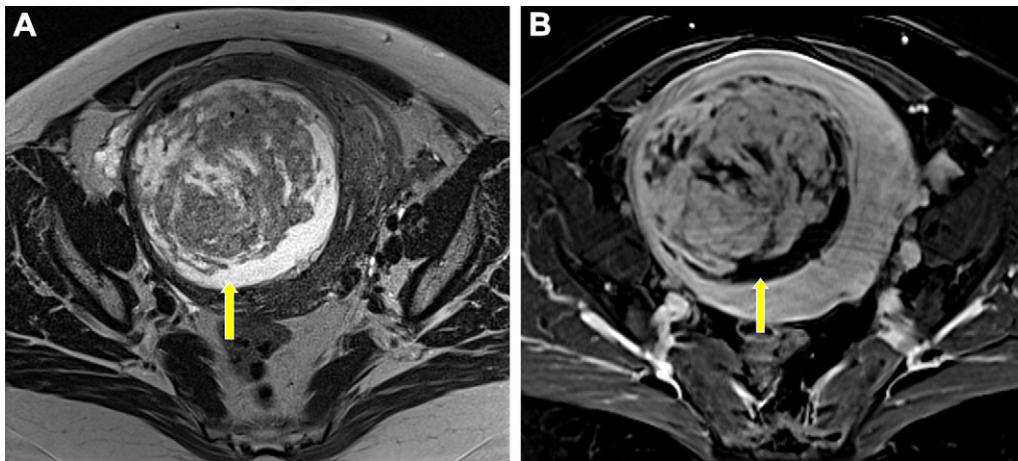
Hydropic leiomyoma in a 51-year-old woman with bulk symptoms, including abdominal bloating, who underwent laparoscopic myomectomy. (A) Axial T2W MR image shows a large FIGO stage 5 leiomyoma (arrow) with heterogeneous signal intensity in the right uterine body. There are confluent areas of T2 hyperintensity, particularly along the periphery of the tumor. (B) Corresponding axial postcontrast T1W fat-saturated subtraction MR image shows a well-demarcated area lacking enhancement (arrow) in the regions of the leiomyoma with T2 hyperintensity, compatible with hydropic leiomyoma.
